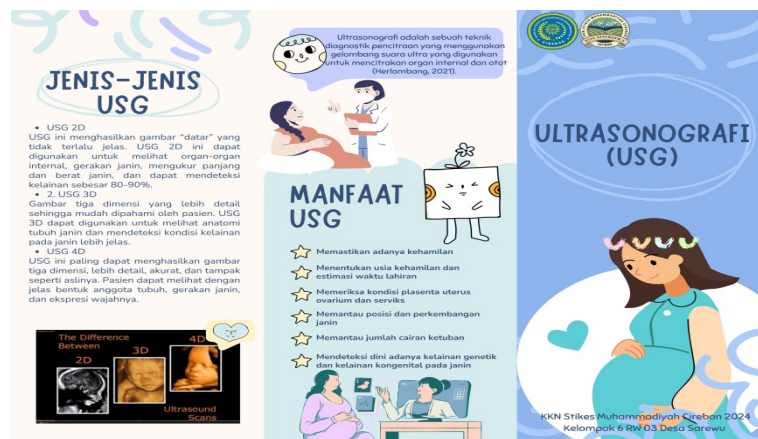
Leaf leaf about ultrasound
